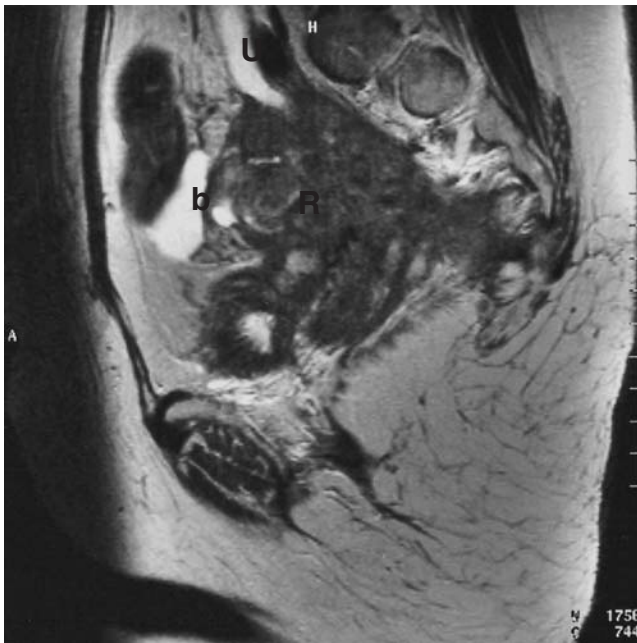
MRI showing recurrent rectal tumour (R) extending to the pelvic side wall and involving the left ureter (U) and bladder (b).
